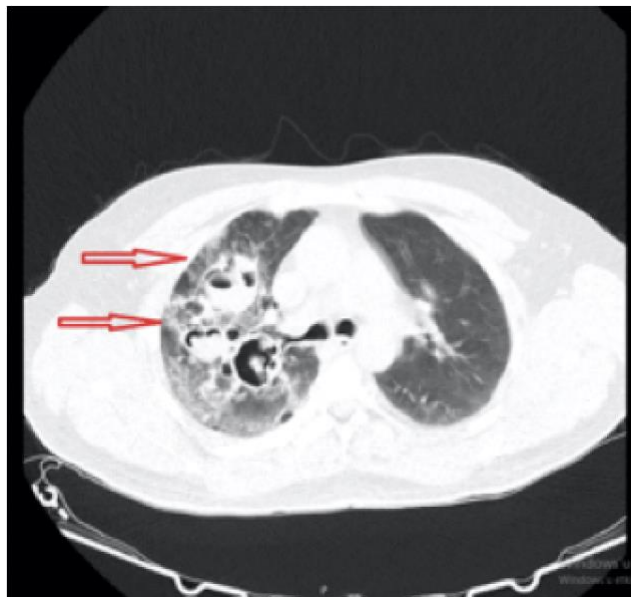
Chest CT findings compatible with chemical pneumonia in the upper zone of the right lung.
